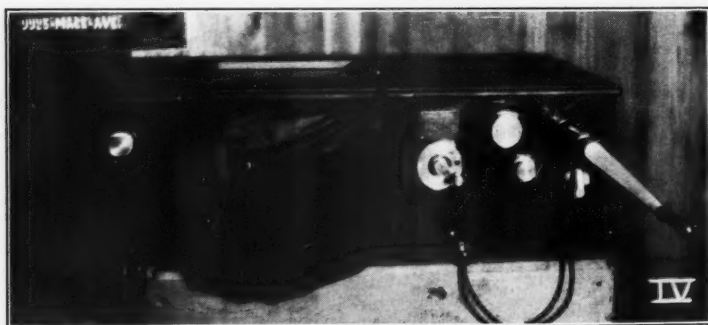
Appearance of Cinex-Camera when closed and ready for use. (One may employ such equipment for serial roentgenography of individual patients or for the efficient handling of a large number of patients with a minimum requirement of time, material, and effort.)
